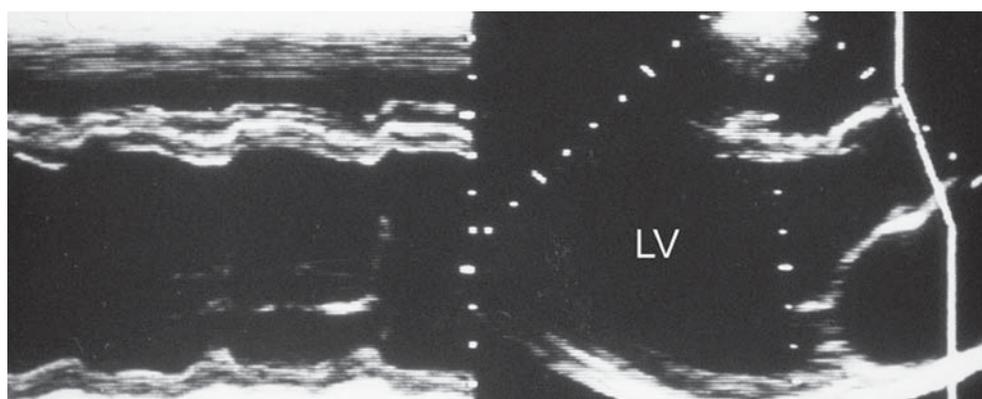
Parasternal long-axis (*top*) and short-axis (*bottom*) from a patient with dilated cardiomyopathy. Note the marked dilatation of the left ventricle
